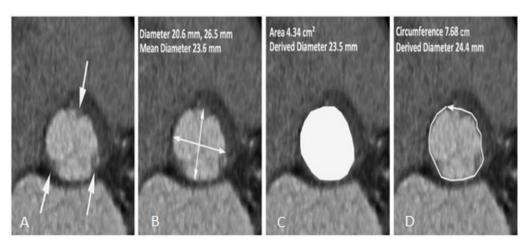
Examples of aortic annular dimensions in MDCT A: shows the three cusp hinge points in the aortic annuals plane, B: Average diameter, C: area, D: perimeter or circumference. SCCT expert consensus document on computed tomography imaging before transcatheter aortic valve implantation (TAVI)/transcatheter aortic valve replacement (TAVR): J. Cardiovasc. Comput. Tomogr., 6 (6) (2012), pp. 366-380 [32]
